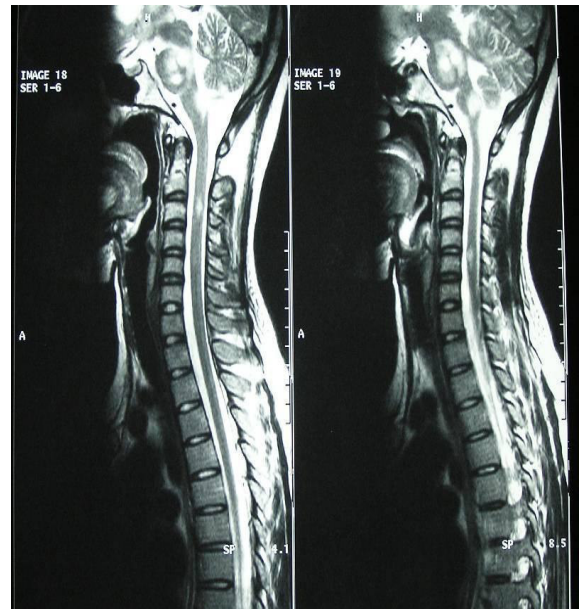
MRI of the cervical and thoracic spine, T1W1 sagittal view show lesion in the spinal cord that enhanced post-contrast noted at C2 and C4/C5 levels.
